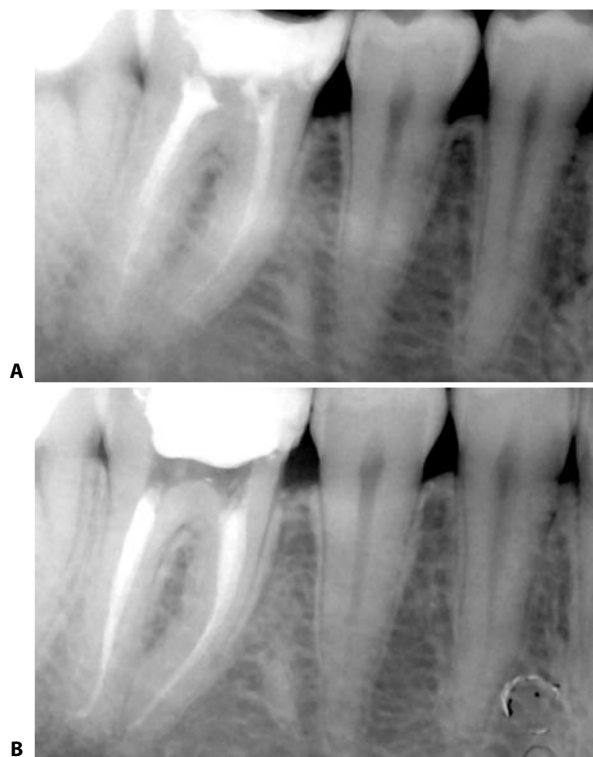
Endodontic retreatment of a lower first molar with narrow and rather long canals. A. Preoperative radiograph. B. Postoperative radiograph. The obturation carried out with the Microseal Technique highlights the maintenance of the canal pathway which is particularly delicate in the apical third.
